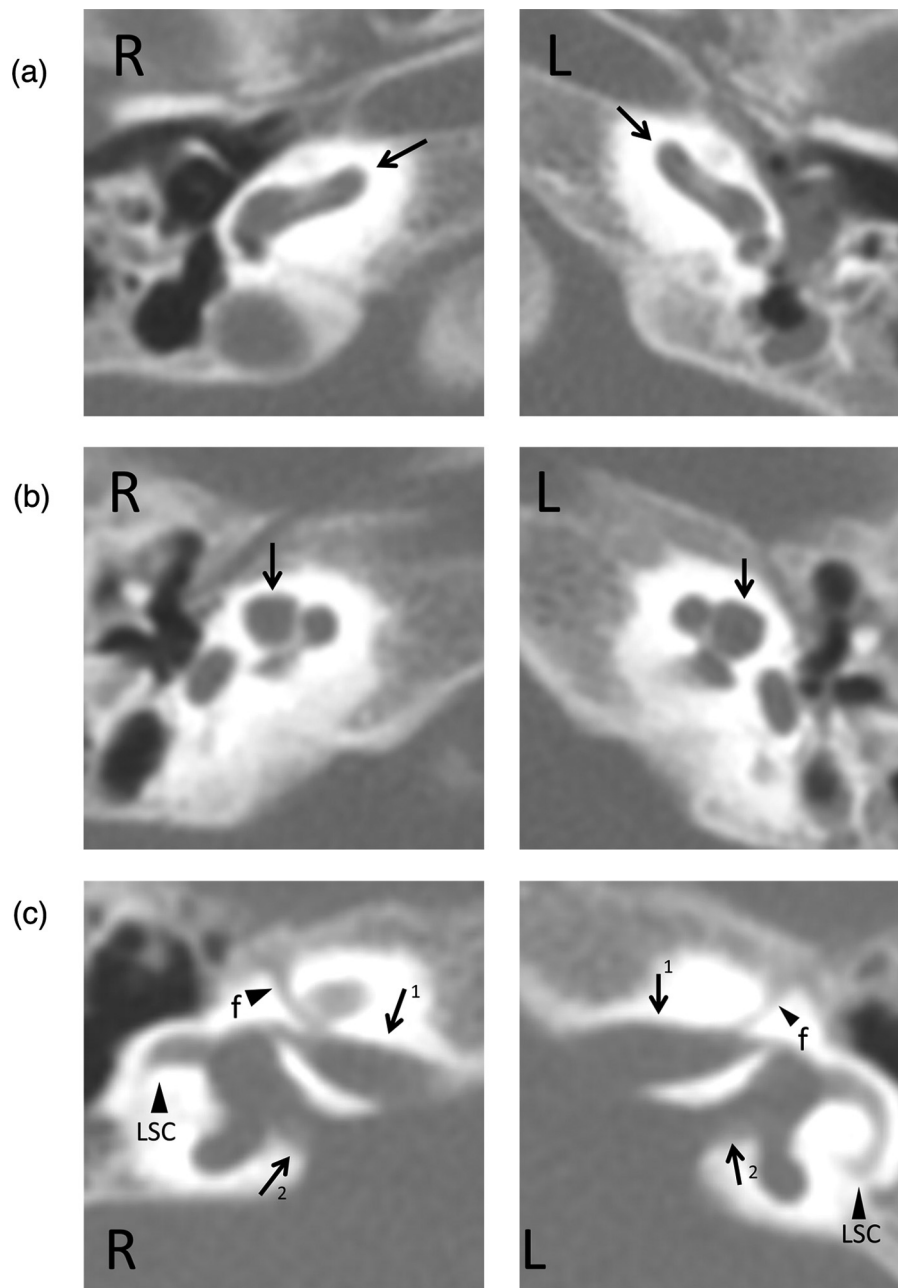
Axial CT images of the inner ear. (a) The basal turn appeared normal bilaterally (arrows). R: right ear, L: left ear. (b) The modiolus was deficient, and the middle and apical turns appeared bulbous due to the absence of the normal interscalar septa (arrows). (c) The anterior internal auditory canal (IAC) (arrow 1) was connected to the labyrinthine portion of the facial nerve and the superior vestibular nerve. The posterior IAC (arrow 2) was connected to the vestibule. The posterior end of the lateral semicircular canal was blind-ended bilaterally. f: the labyrinthine portion of the facial nerve, LSC: lateral semicircular canal.
